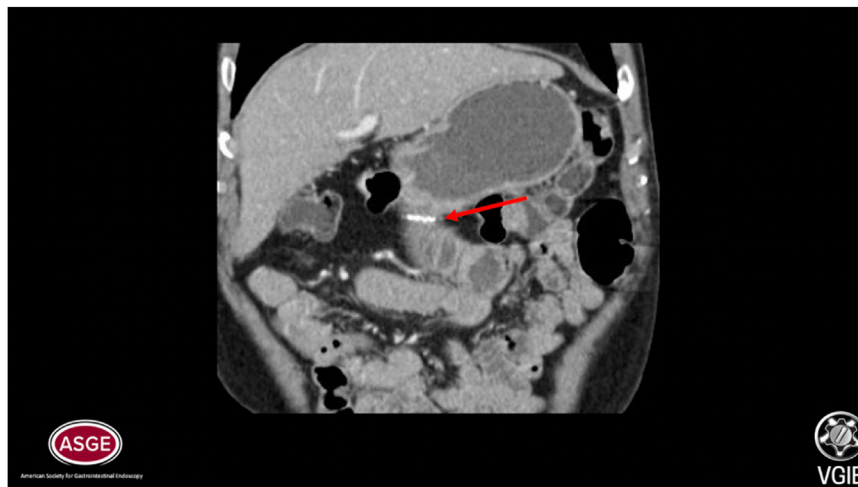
CT of the anatomy before the endoscopic septotomy. Notably, the orientation of the small bowel with the stomach is amenable to EUS-guided gastrojejunostomy. The stricture is denoted by a *red arrow*.
